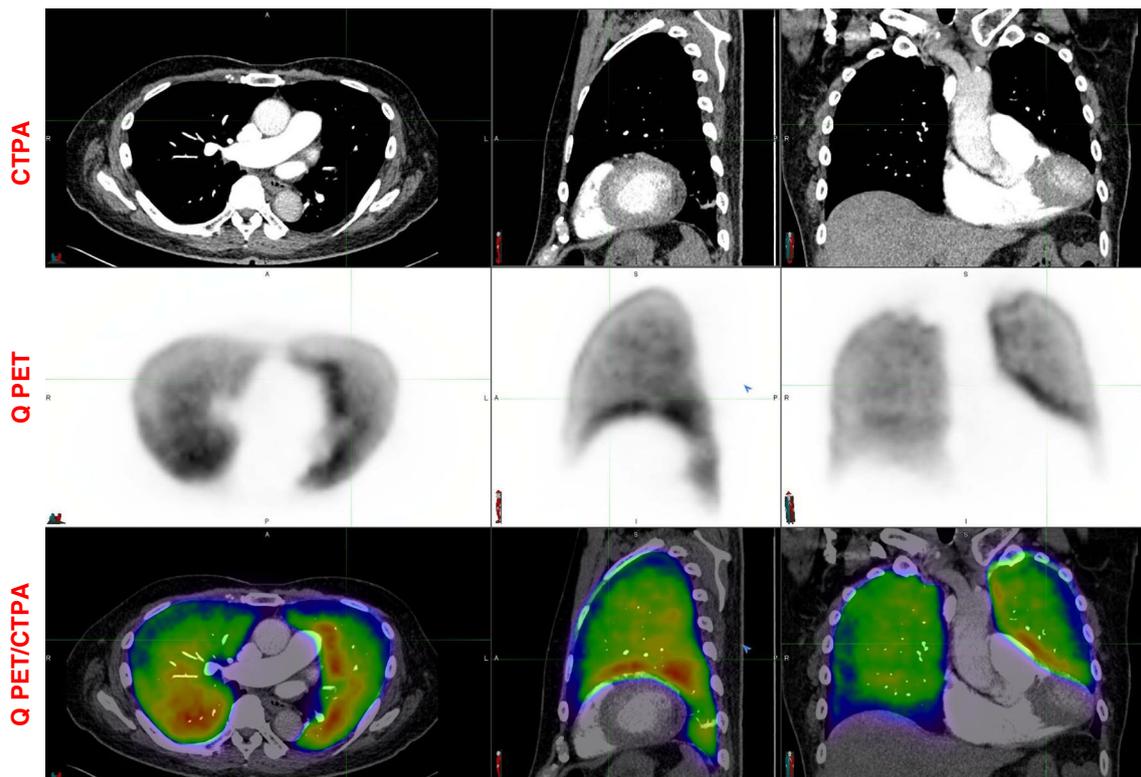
The CTPA images show one isolated subsegmental thrombus in the lingula. The V/Q PET/CT and coregistered Q PET/CT images are negative for PE with no perfusion abnormality beyond the clot
